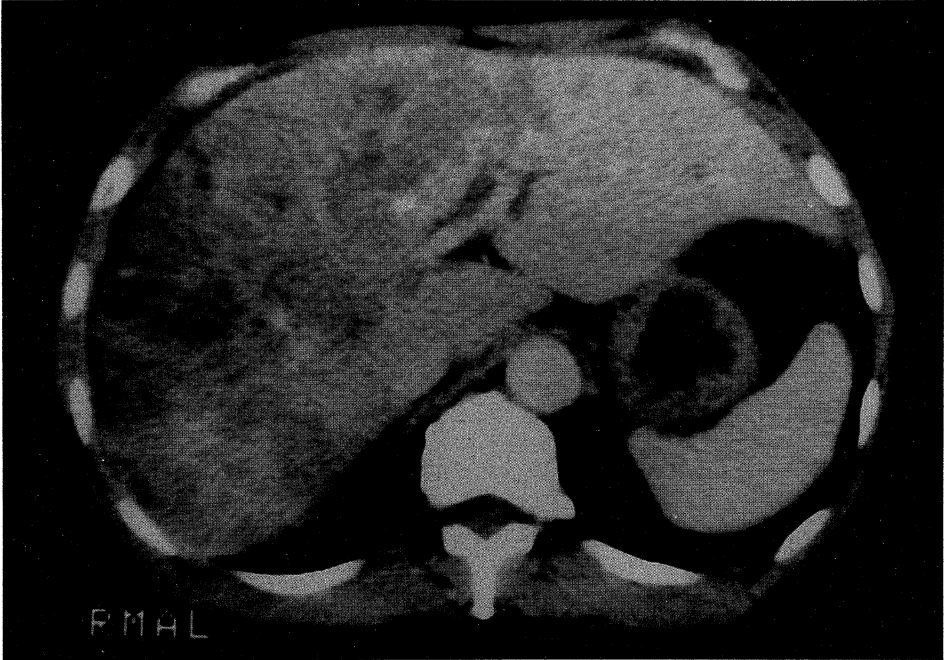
An abdominal CT-scan on admission
